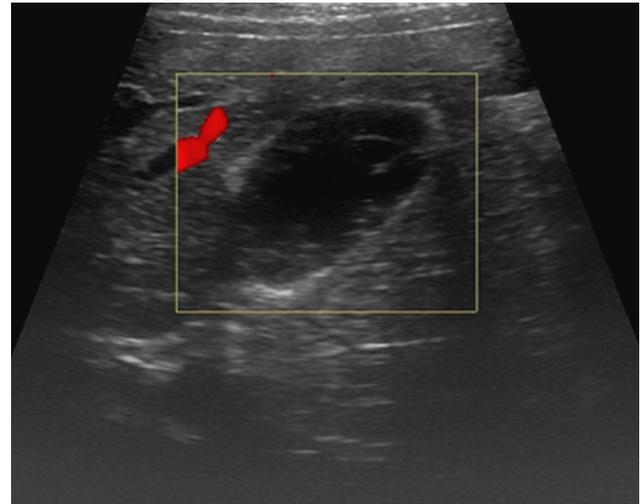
Sagittal doppler ultrasound images of gallbladder. Note that the septa are hypovascular in doppler ultrasound imaging.
